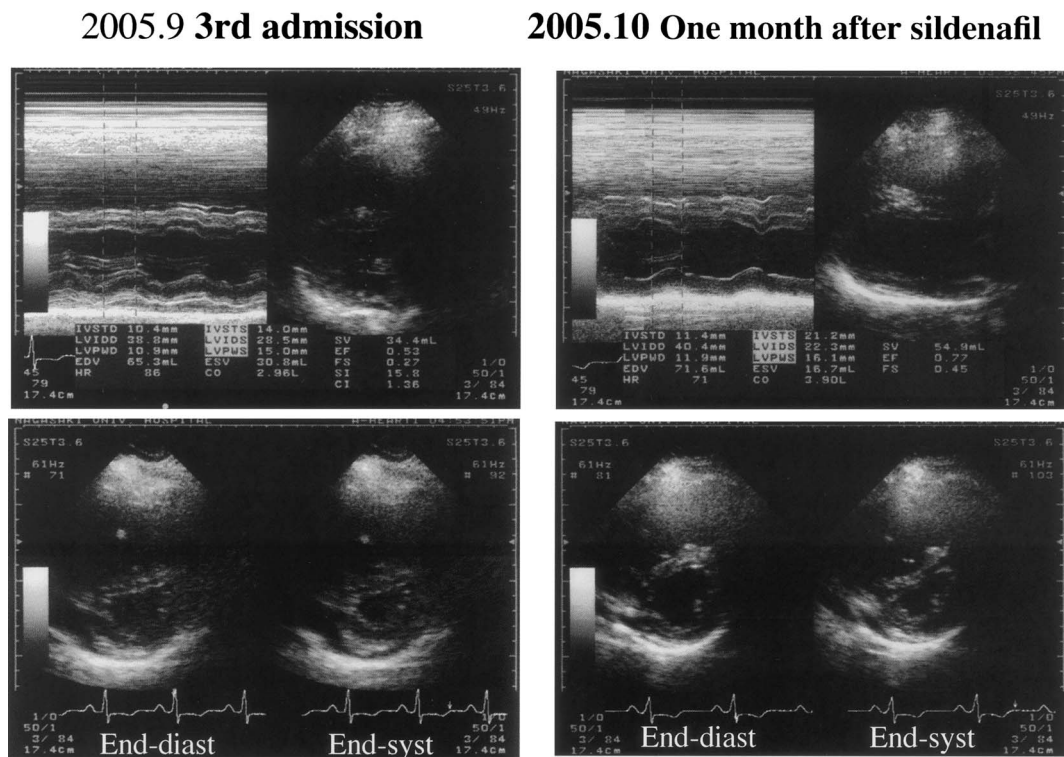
Echocardiographic changes. Before sildenafil administration, the interventricular septum (IVS) was flattened and mild pericardial effusion was seen at the end-diastolic and the end-systolic phases (A). At 1 month after the treatment, pericardial effusion disappeared and the flattening of IVS also disappeared at the end-diastolic phase (B). End-diast, end-diastolic phase; End-syst, end-systolic phase.
